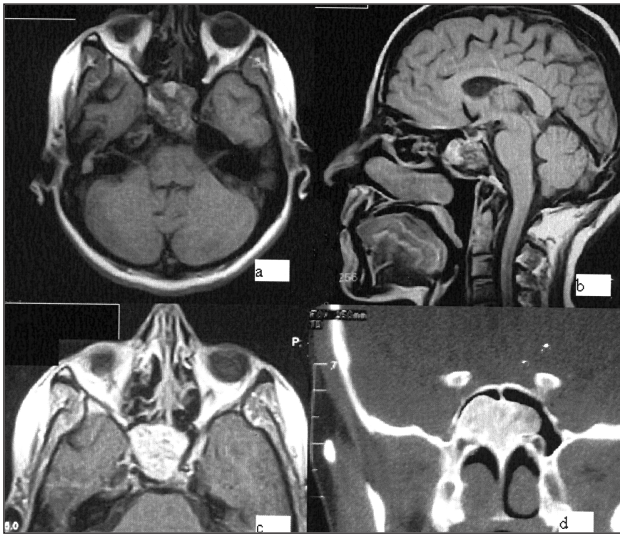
Preoperative axial (A) and sagittal (B) T1-weighted MRI scans display a large heterogeneous mass lesion in the sphenoid sinus region. Preoperative axial MRI view with IV-Gadolinium (C) shows that the mass lesion strongly enhances with contrast media. Preoperative coronal paranasal sinus tomography (D) shows a hyperdense mass filling mainly the right side of sphenoid sinus.
